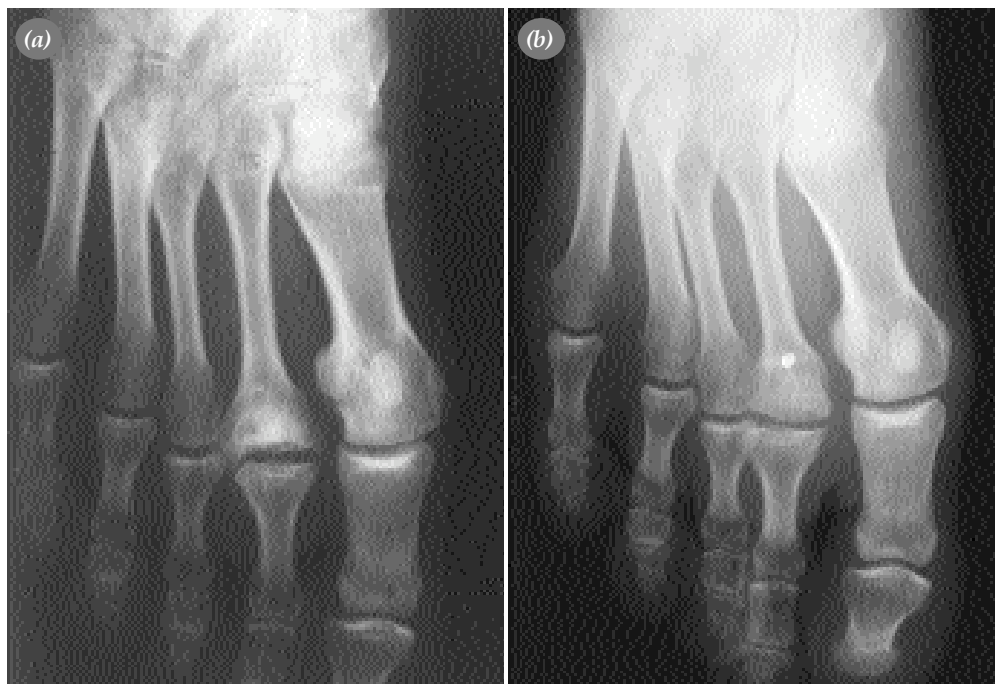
A patient preop. and postop. X-ray
